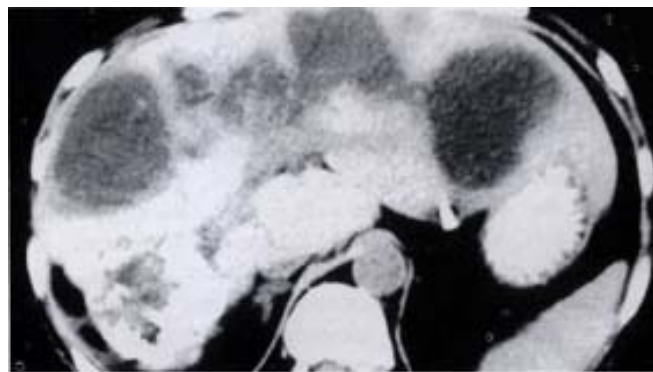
Biliary abscess of liver after HAE. CT shows multi-abscess along portal tract.
